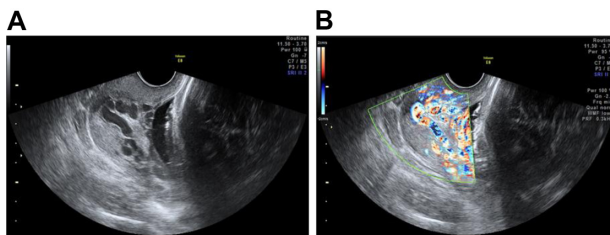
Transvaginal ultrasound image at 34 weeks of gestation shows severely dilated tortuous blood vessels replacing most of the normal cervical tissue (B) power Doppler.
